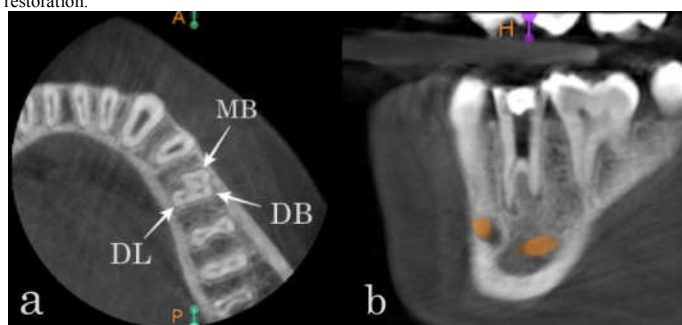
Oblique (a) & axial (b) views CBCT images of tooth #35
